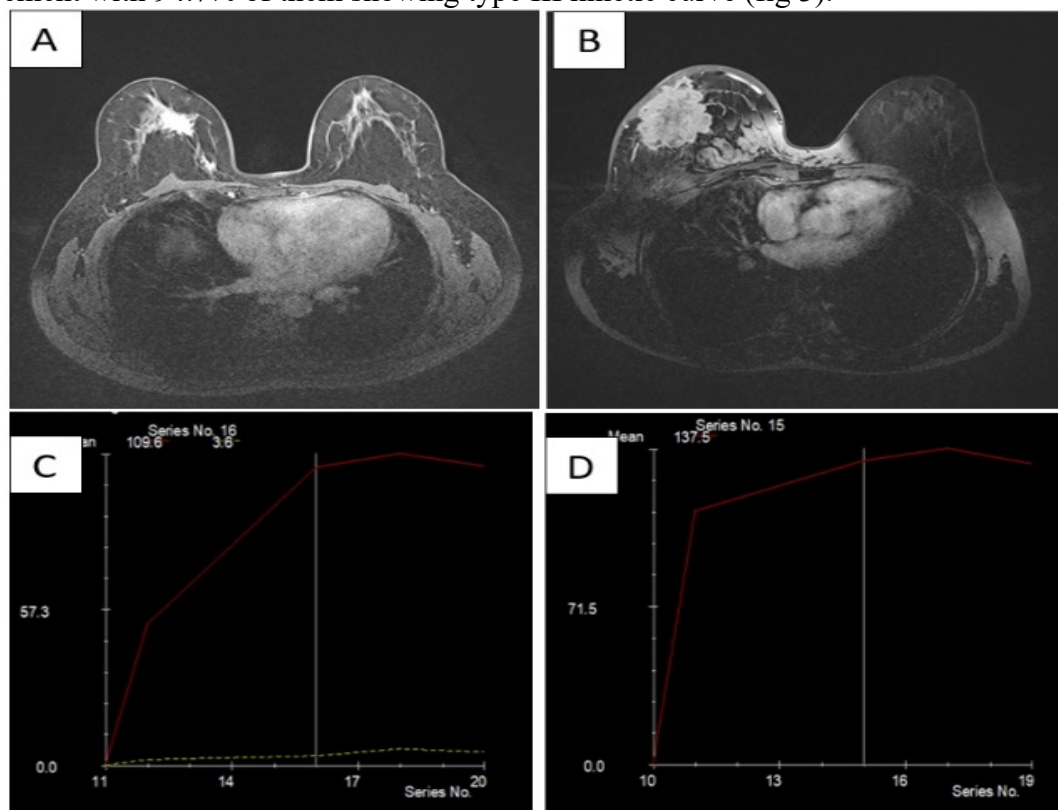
Subsequent DCE-MRI of the 1st patient shows homogenous pattern of enhancement (A) and washout out kinetics (type III curve) was found on kinetic curve analysis (B). In the 2nd patient heterogeneous pattern of enhancement (C) and type III curve (D) was found.
